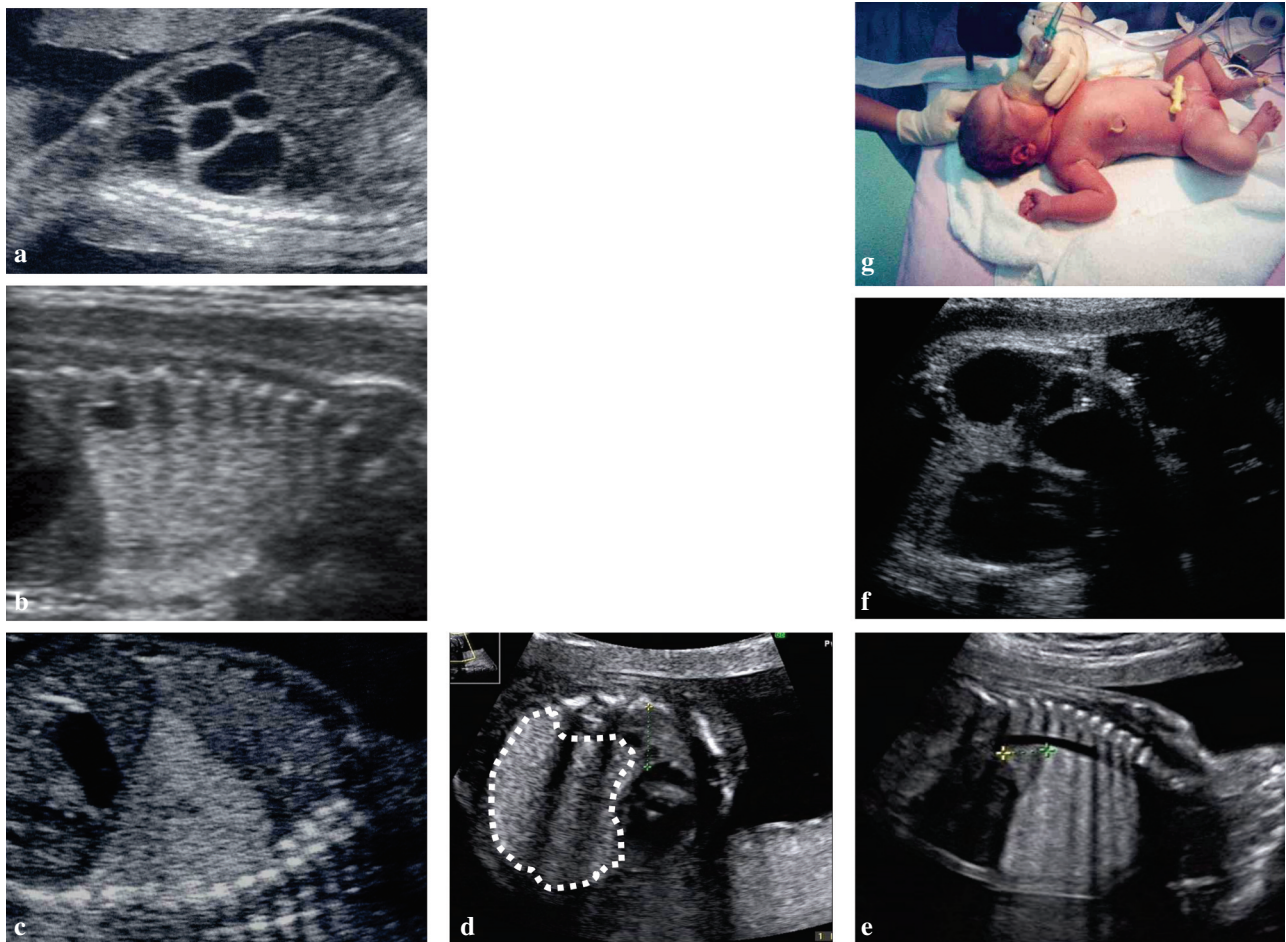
Cystic Adenomatoid Malformation (CCAM) of the fetal lung. The condition is usually described as either type I (a), II (b) or III (c, d) based on the presence and size of visible cystic areas on the ultrasound image. (d) Dotted line delineates the type III lesion; remnant lung is squeezed between lesion, heart and thorax on transverse and longitudinal section. (e) MR image of cystic lesion. (f) Shunted cystic lesion, with tip of pigtail visible on ultrasound both sides of the thorax wall and at birth (g).
